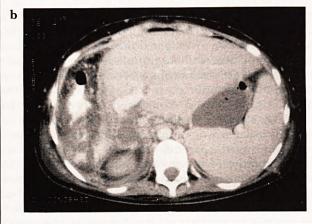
CT appearances (a) before (b) 20 days after extensive right hepatic resection for tumour. Note the striking increase in the size of the left lobe of the liver
